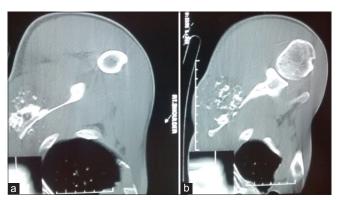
(a and b) An axial computed tomography scan view of the right scapula shows eroded cortex of the scapular blade with intact acromion process and glenohumeral joint
